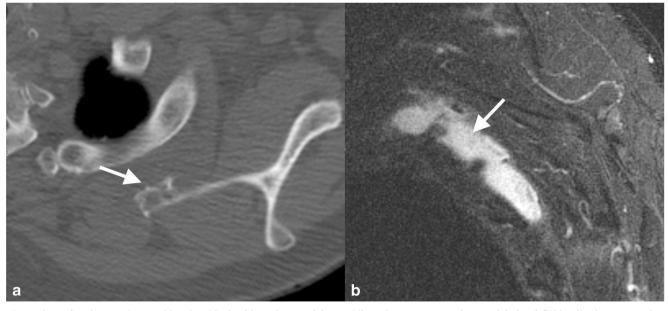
Osteochondroma. 73-year-old male with shoulder pain. a Axial CT shows an osseous protuberance arising from the superior scapula (arrow) with resultant decreased scapulothoracic distance. b Sagittal
